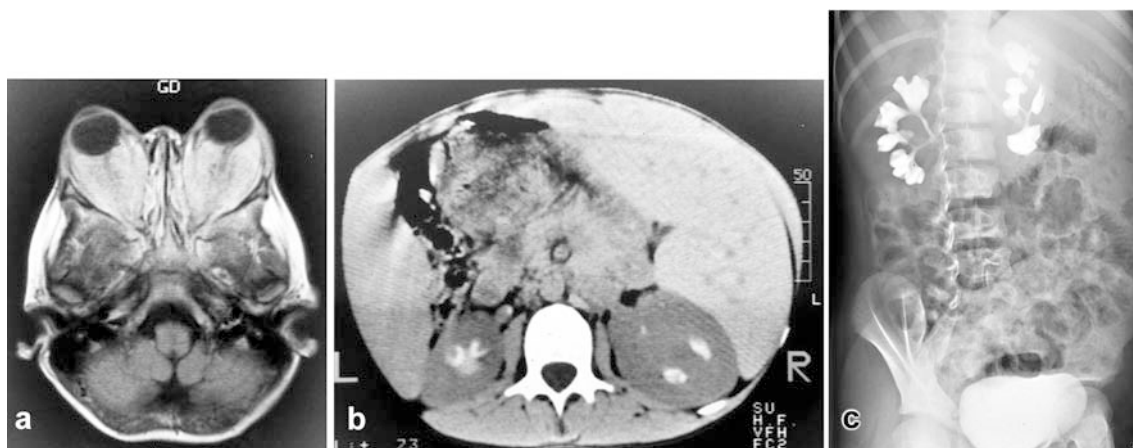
A 4-year-old boy with extranodal multisystem Rosai-Dorfman disease. a Contrast-enhanced brain CT shows bilateral expansive intraconal infiltration of retro-orbital fat by histiocytes. The adjacent osseous structures, globes and optic nerves are spared; the latter are surrounded by the inflammatory process. b Abdominal CT demonstrates massive proliferation of histiocytes within the hilus and pelvis of both kidneys with compression of calyces and ureters. These features are also seen on intravenous urography (c). There was concomitant invasion of the lumbar and sacral spinal canal, including the anterior epidural space and both foramina on MRI (not shown)
